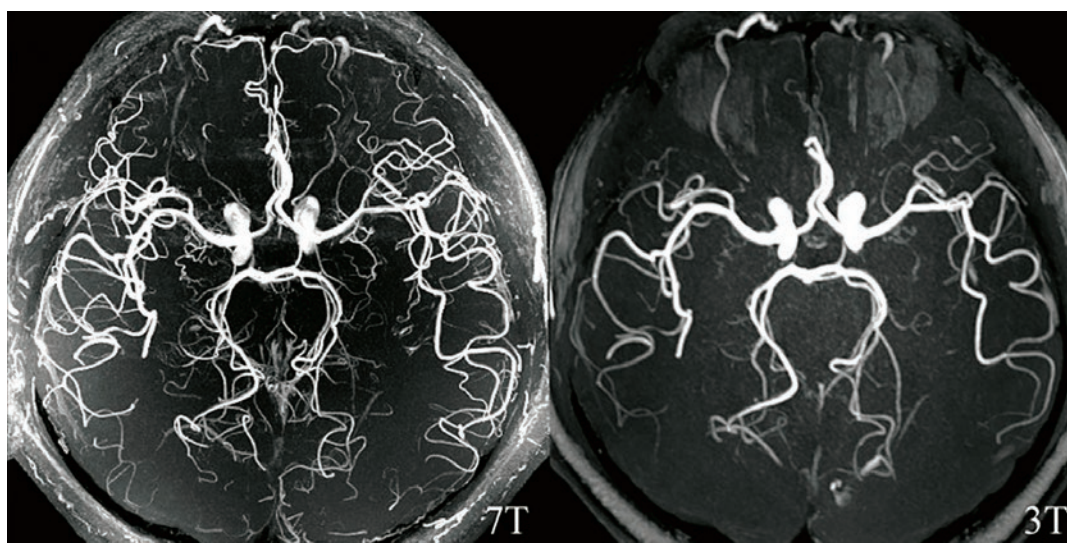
MRI angiography on 3T and 7T MRI
